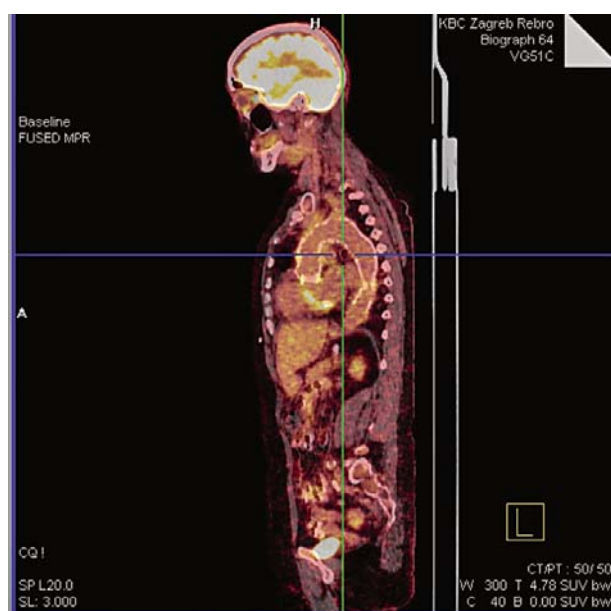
Patient's PET CT scan (June 2017)
